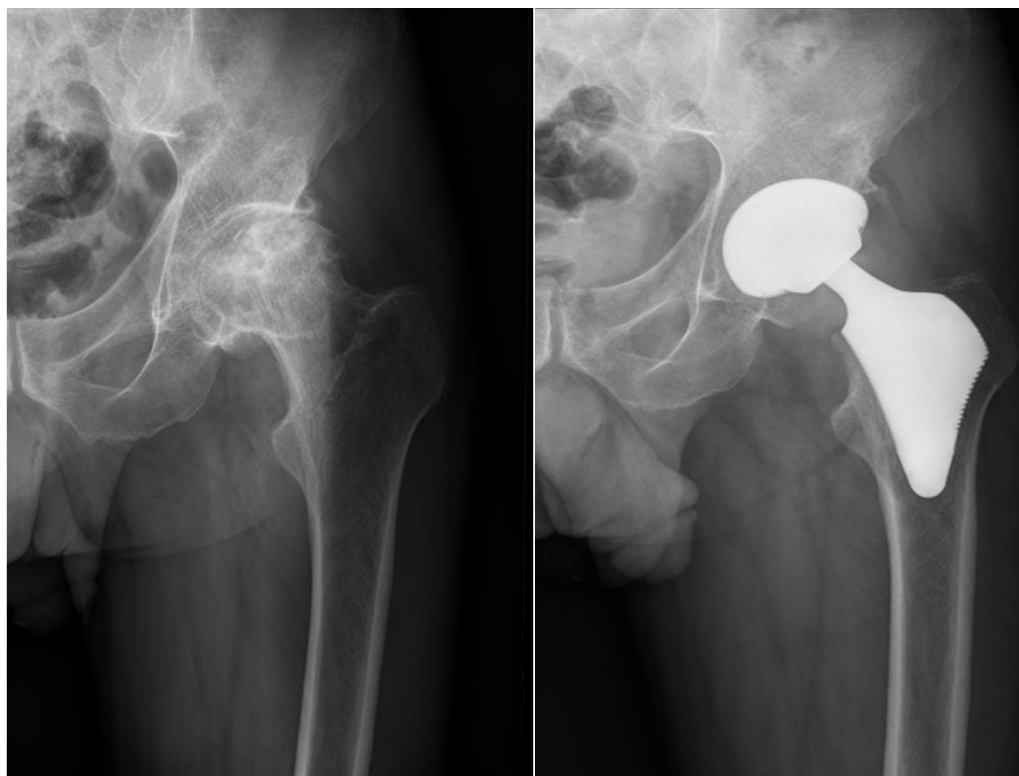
Anteroposterior and lateral radiographs of a 48-year-old man with osteonecrosis of left femoral head. A: Preoperative radiograph of left hip demonstrates collapse of left femoral head (Ficat stage IV) and Dorr type C femur; B: Postoperative radiograph of left hip obtained 17 years after the operation. The acetabular component and a calcar loading with a lateral flare anatomic cementless femoral component are well fixed in a satisfactory position without radiolucent line or osteolysis.
